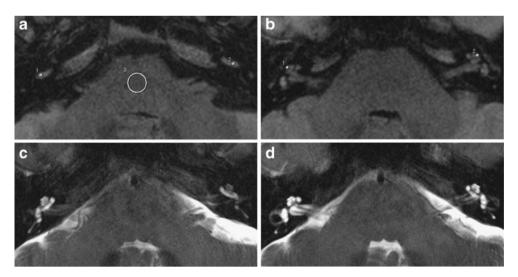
3D-FLAIR images at the levels of the cochlear basal turns (a) and apical turns (b) after intravenous gadolinium injection (IV method) of a 38-year-old man who was suspected to have bilateral Ménière's disease are presented. The identical slices of 3D-TSE T2WI are also presented (c, d). The intravenous gadolinium injection was administered 4 h prior to MRI, and the perilymph of both inner ears shows a
